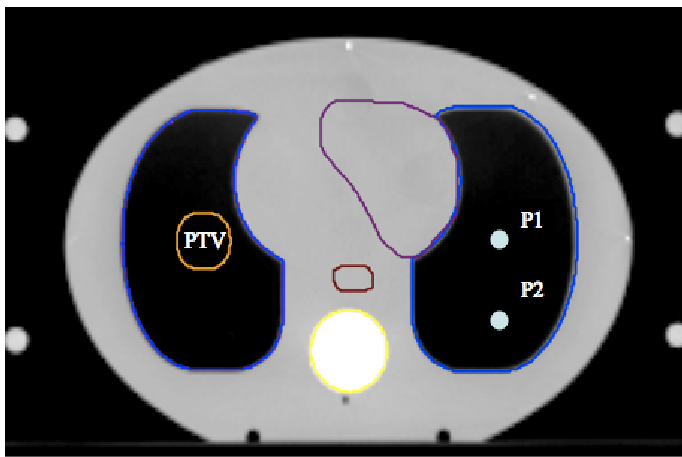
Transverse CT slice of the CT showing the PTV, contoured structures, and the points of measurement. P1 is the medial point and P2 is the posterior point of measurement on the contralateral lung equivalent material.
